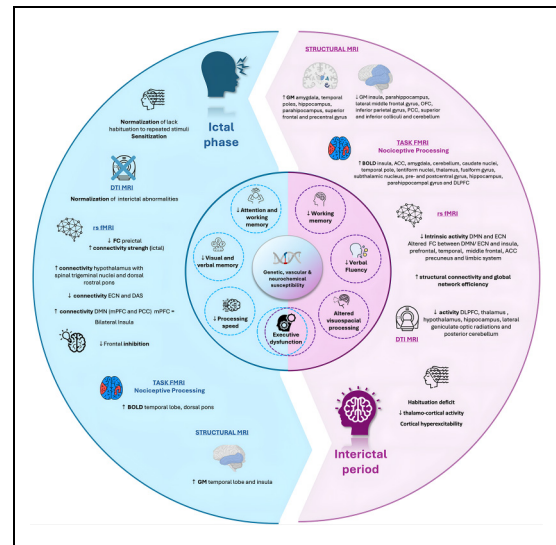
Pathophysiological mechanisms of migraine-related cognitive dysfunction. Cognitive dysfunction susceptibility in migraine is modulated by genetic, vascular and neurobiochemical factors. Surrounding this core, cognitive complaints may emerge across different migraine phases (i.e. ictal, perictal and interictal), each associated with distinct symptom profiles and the involvement of specific brain networks. Cognitive impairment during these phases can be explained by neurophysiological evidence of altered cortico-subcortical communication, as well as neuroimaging findings, particularly (magnetic resonance imaging (MRI), which highlight changes in network connectivity, dynamics, and plasticity. ACC = anterior cingulate cortex; CEN = central executive network; DMN = default mode network; DAS = dorsal attention system; DLPFC = dorsolateral prefrontal cortex; DTI = diffusion tensor imaging; FC = functional connectivity; GM = gray matter; mPFC = medial prefrontal cortex; PCC = posterior cingulate cortex; PFC = prefrontal cortex; RI = right inferior.
